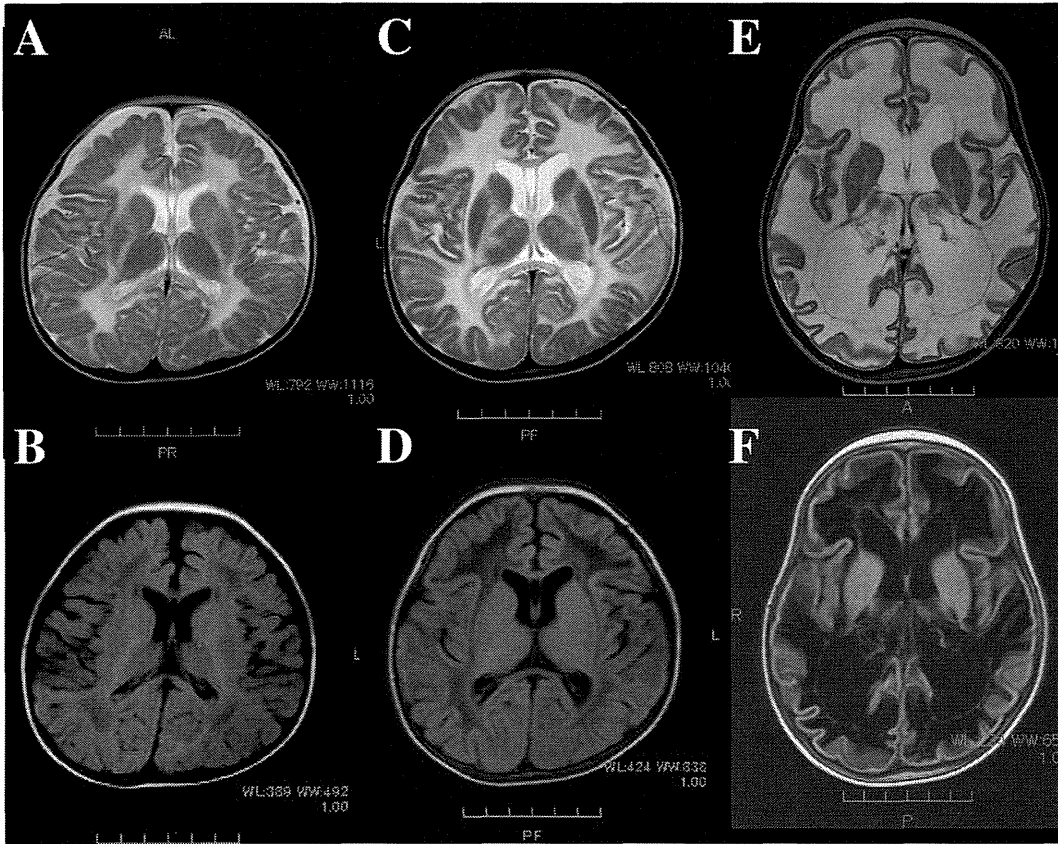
Axial T2-weighted (A, C, E) and FLAIR (B, D, F) images of the patient. The first brain MRI at the ages of 5 months shows diffuse bilateral symmetrical abnormal intensity of the deep white matter (A and B). Images obtained 3 months later exhibits expansion of the white matter lesion with involvement of part of the thalami and the globus pallidus (C and D). The latest images obtained at the age of 25 months shows that whole white matter has abnormal intensity, similar to cerebrospinal fluid, indicating cystic degeneration and the thalami and the globus pallidus are totally involved (E and F). Brain atrophy is not observed.
